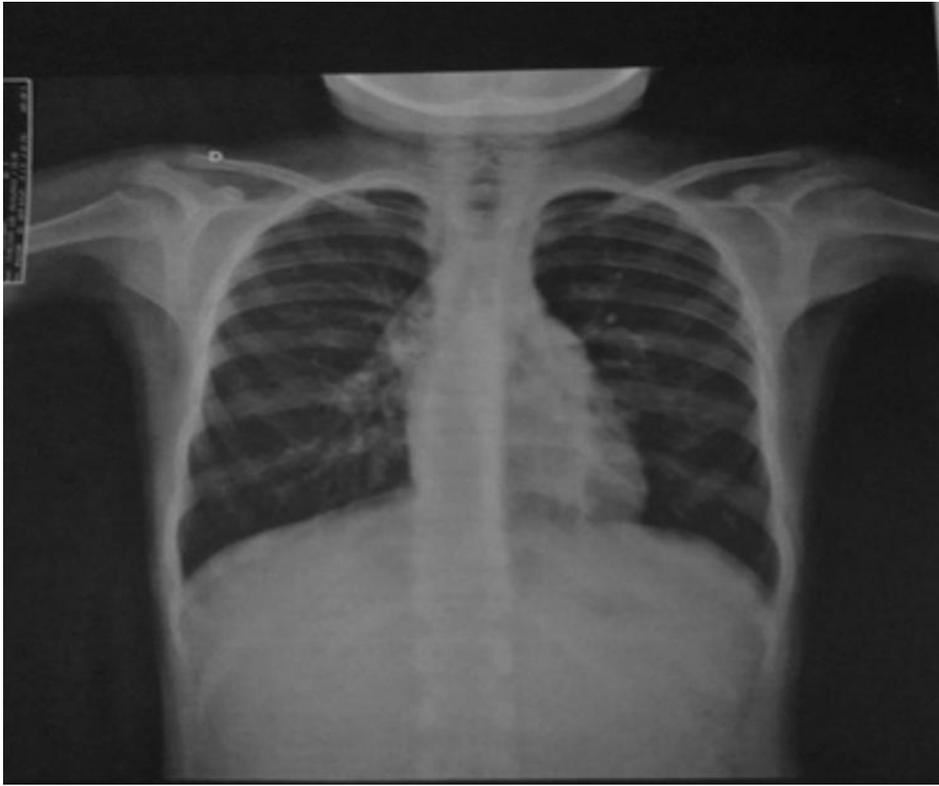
Chest radiography: dextrocardia.
